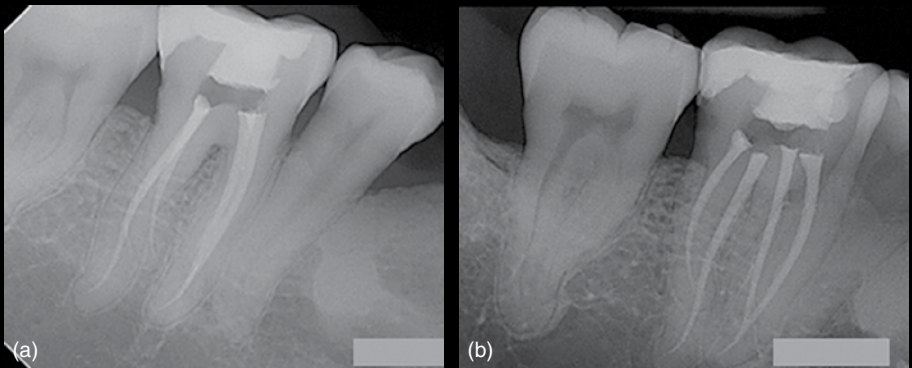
(a) Post-operative periapical radiographs and (b) parallax view.
